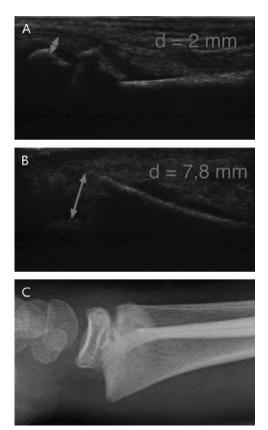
Aitken-1 fracture of the distal radius; dorsal (A) and palmar (B) view by ultrasound and lateral x-ray view (C).
